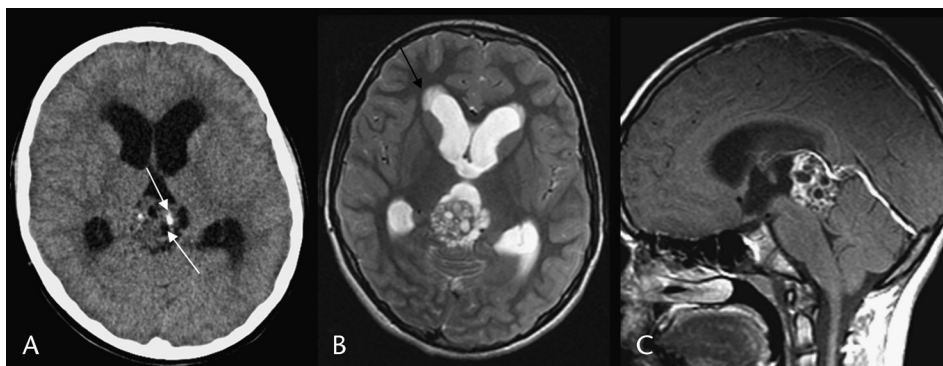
Mixed germ cell tumor with teratoma. Noncontrast CT (A) shows a heterogeneous pineal region mass with calcification and cysts (white arrows), but no fat. Hydrocephalus with edema is present. Axial T2 (B) and sagittal gadolinium T1 (C) images show a lobular cystic and solid mass that irregularly enhances. Third and lateral ventriculomegaly is present along with periventricular edema (black arrow). Biopsy of the mass was done during ETV.
